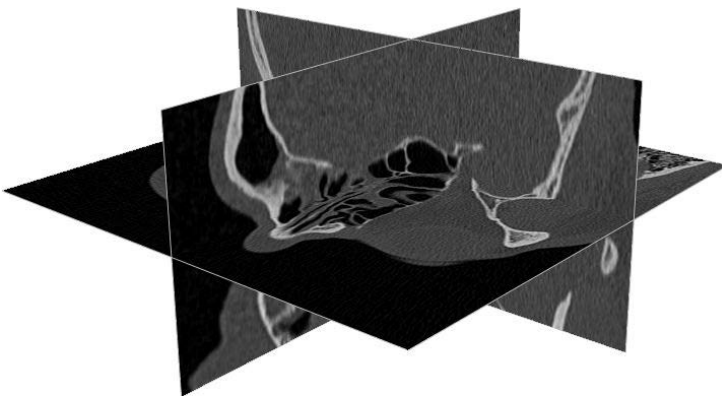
3D multi-planar reformatting (MPR) visualization of a CT image of the facial skeleton. The user can explore the CT image by translating the three orthogonal planes along the image axes
